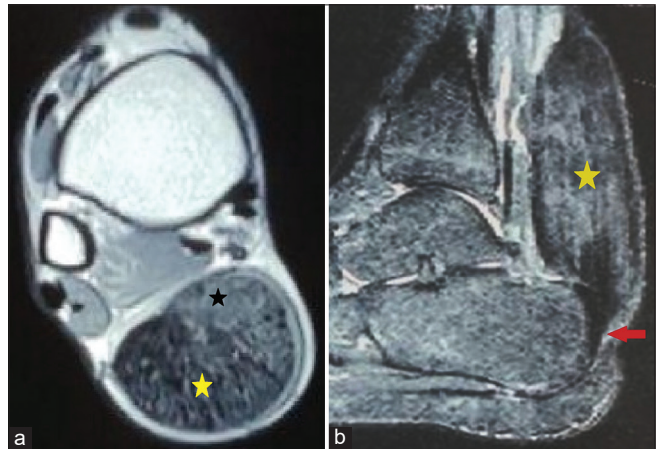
(a and b) Axial T1 (a) and sagittal short-TI inversion recovery (b) MR images of the ankle demonstrate fusiform enlargement of Achilles tendon with thickened fibers (yellow asterisk). A focal T1 isointense signal lesion (black asterisk) in the anterior medial aspect of the enlarged tendon. The calcaneal attachment of the Achilles tendon (red arrow) is normal.
